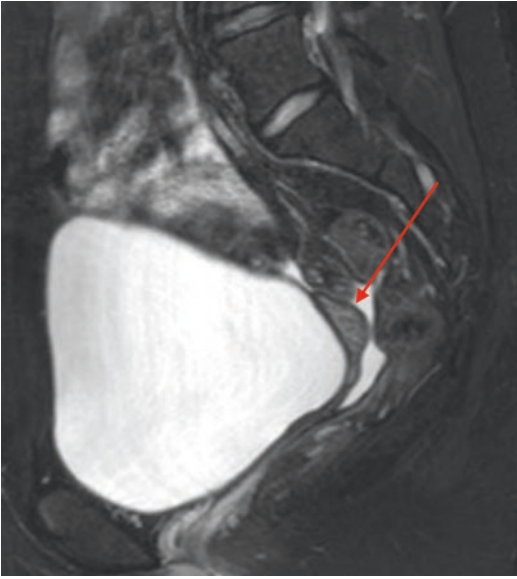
Pelvic MRI of a Müllerian anomaly. T2-weighted magnetic resonance imaging (MRI) of the patient from Fig. 2.2. The hypoplastic uterine structure (red arrow) posterior to the distended bladder does not show an endometrial stripe and there is no vaginal structure
